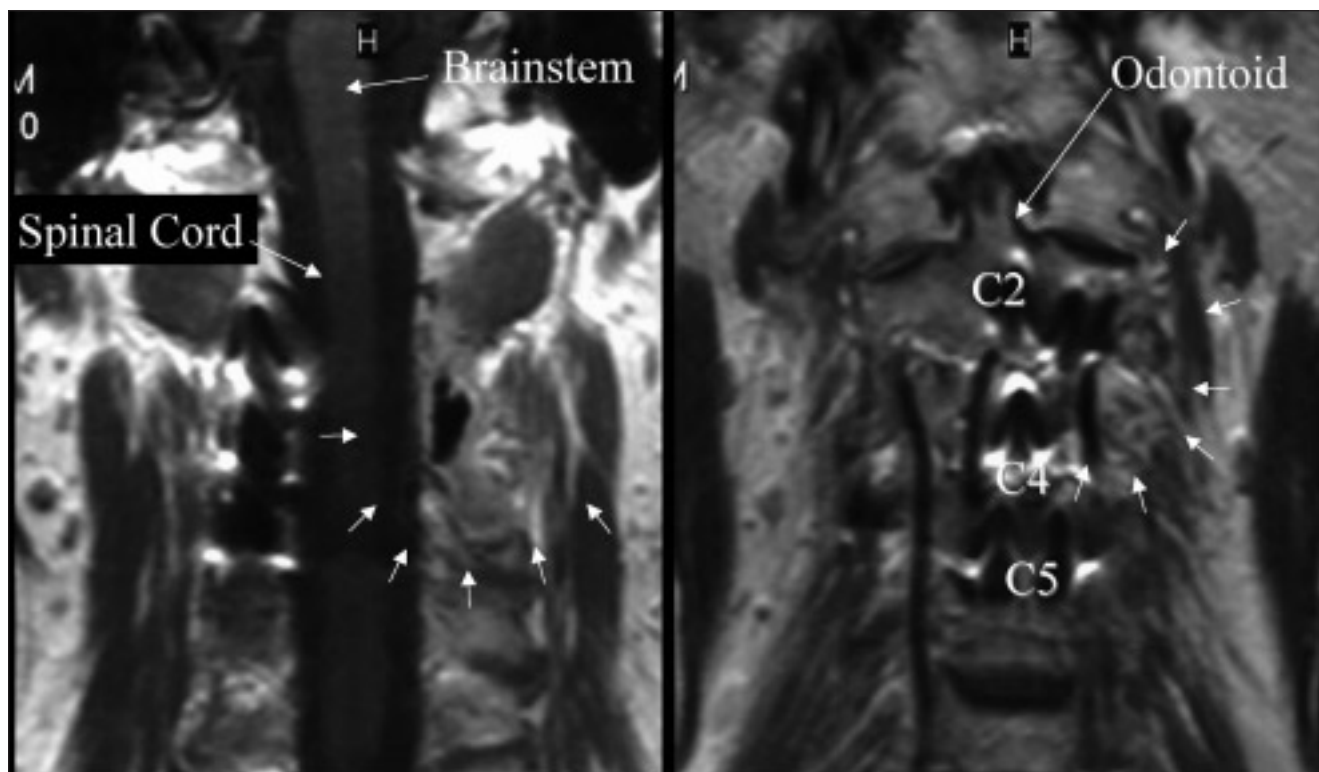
Postoperative gadolinium-enhanced magnetic resonance images show no residual enhancement. Arrows show preoperative location of the tumour.
